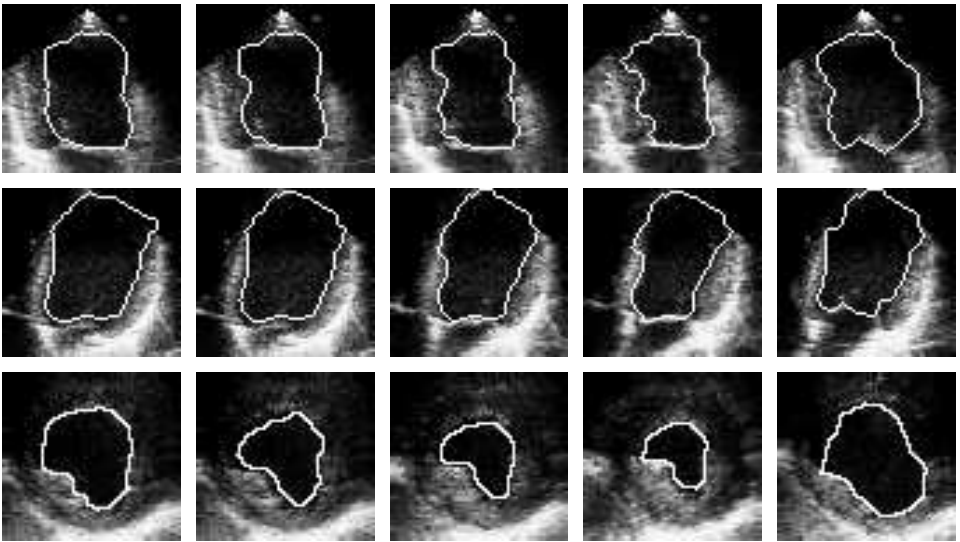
Contour tracking of a human left ventricle from four 2D ultrasound sequences corresponding to different orientation planes. (Upside) Apical two chamber view. (Middle) Apical four chamber view. (Bottom) Parasternal short axis view.
